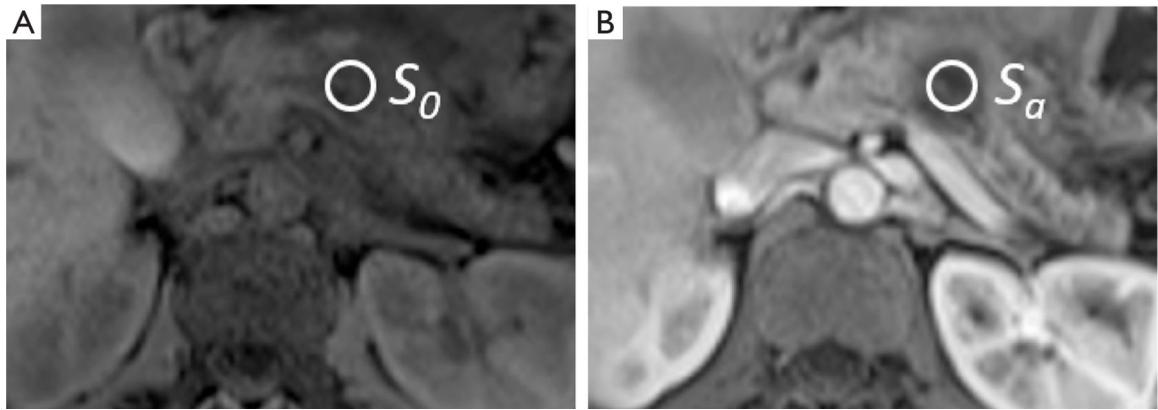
Example ROIs for patient 1. ROIs (white circles) of the pancreatic mass on T1-weighted axial (A) non-contrast image of the abdomen (S_0) and (B) arterial phase image of the abdomen (S_a). ROIs, regions of interest.
